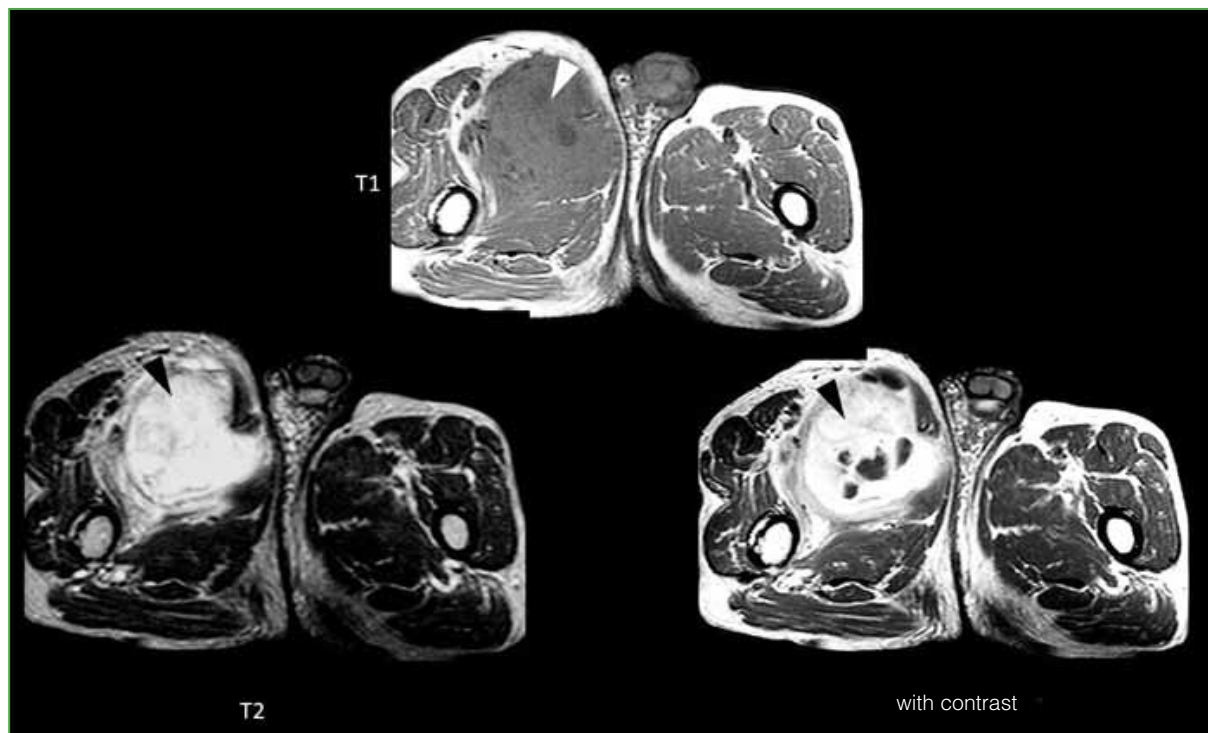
MRI of the pelvis with contrast medium. In the T1-weighted sequence, an expansive lesion with an intermediate signal is observed in the inner region of the proximal third of the right thigh. In the T2-weighted sequence, the lesion is evidently hyperintense. Following the injection of the contrast medium, a marked enhancement is seen with central areas of low signal not taking up the contrast medium.
